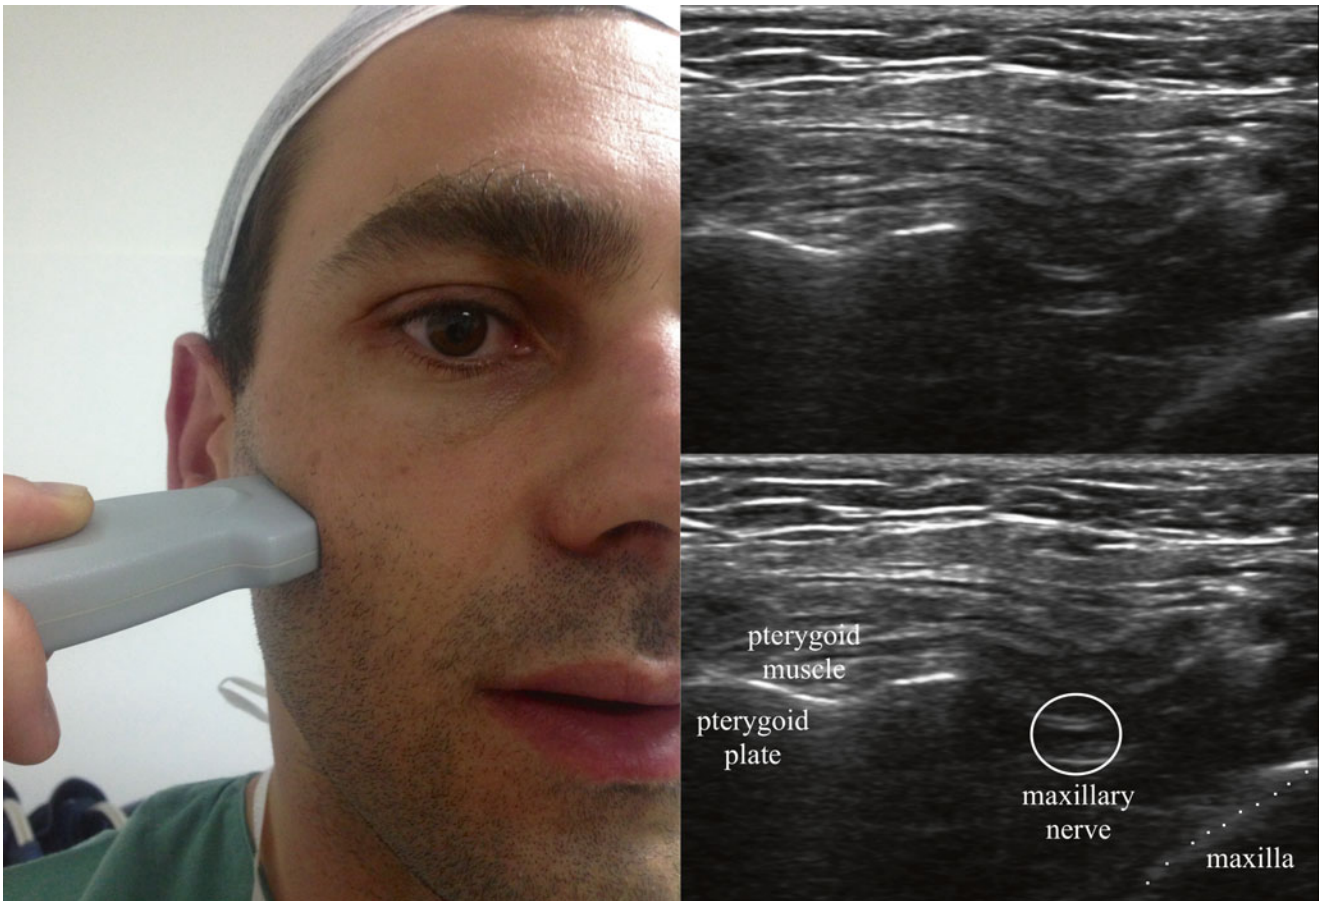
Ultrasound image of the maxillary nerve (Image courtesy of Thiago Nouer, MD)
